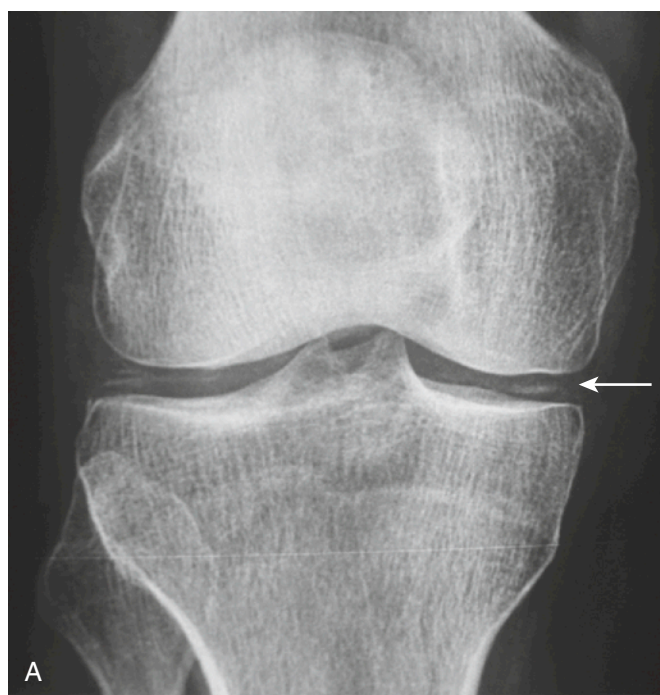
CALCIUM PYROPHOSPHATE DIHYDRATE DISEASE OF THE KNEE. A, The radiograph shows meniscal calcifications (*arrow*). B, Ultrasound demonstrates hyperechoic deposits (*arrow*) at the medial meniscus on a longitudinal medial view. f, femur; t, tibia.
